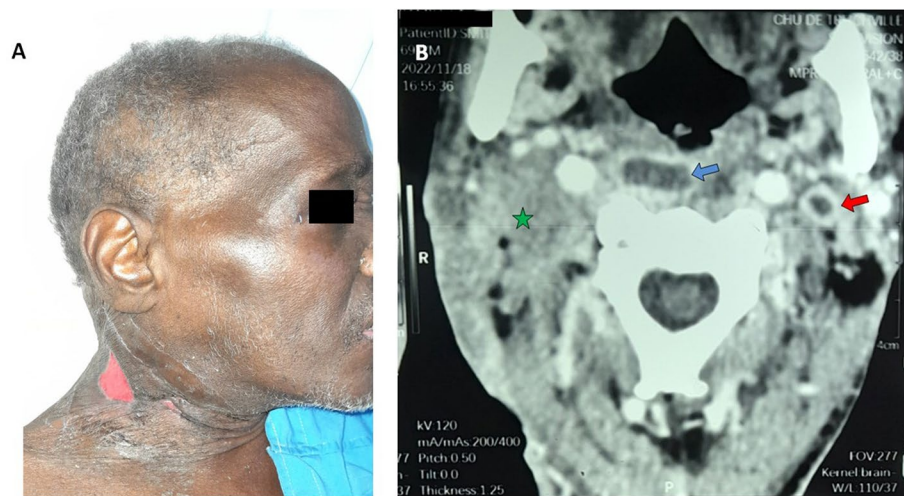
Patient 6. A Right cervical skin loss of substance. B Cervical CT scan (axial section) with contrast injection showing bilateral internal jugular vein thrombosis (red arrow, thrombosis of the left internal jugular vein; blue arrow, retropharyngeal abscess; green star, right internal jugular vein non-visible due to thrombosis)
